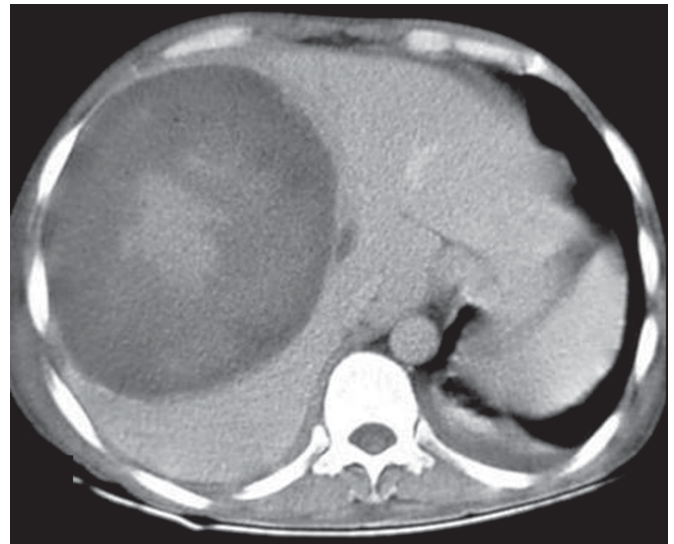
Axial non-contrast CT image in a patient with hepatic adenoma shows a large hypodense mass in the right lobe of the liver. The hyperdense areas within the mass represent areas of haemorrhage.
